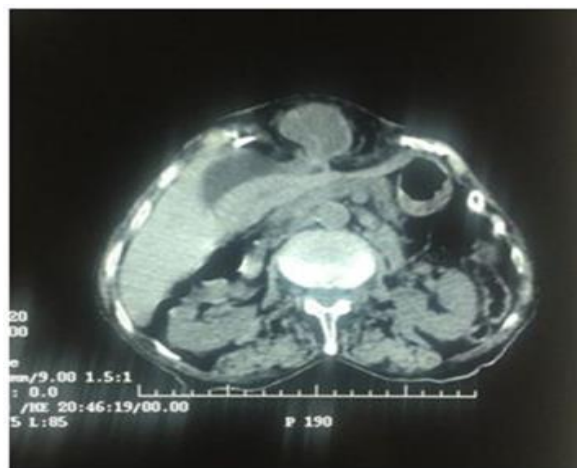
CT scan in axial view with intravenous injection contrast showing a voluminous mass of the gall bladder; with fistulization of the anterior abdominal wall.
